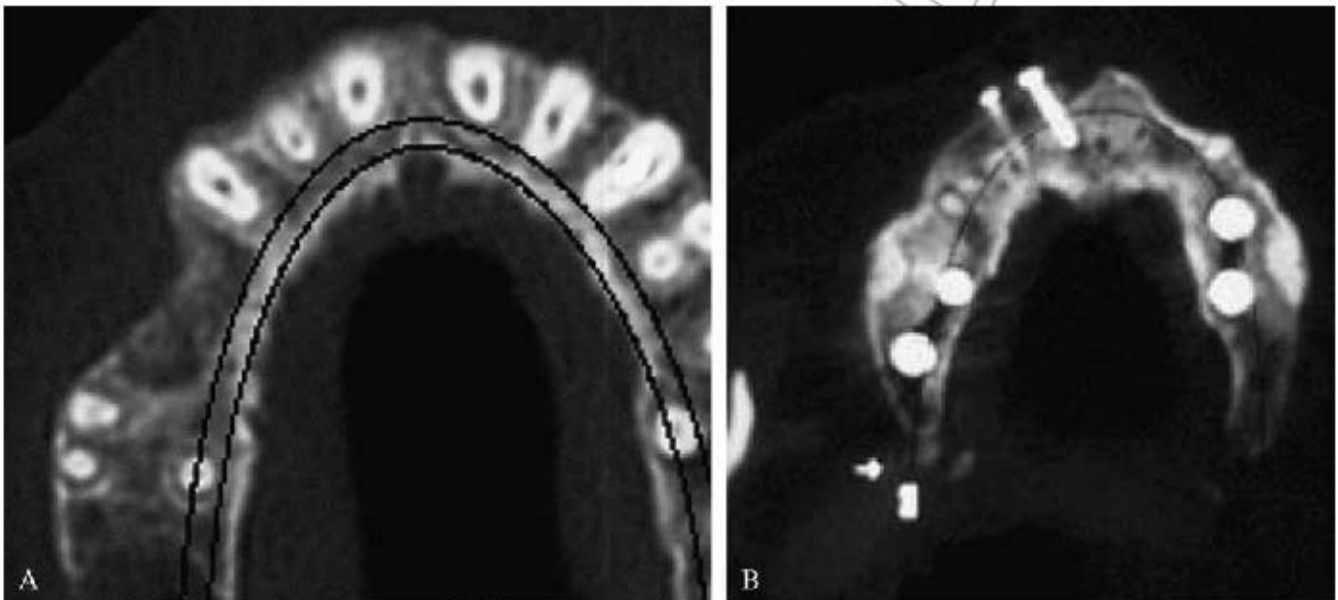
CT-images were needed to assess the possibility of placing implants with standard procedures or alternatively.
